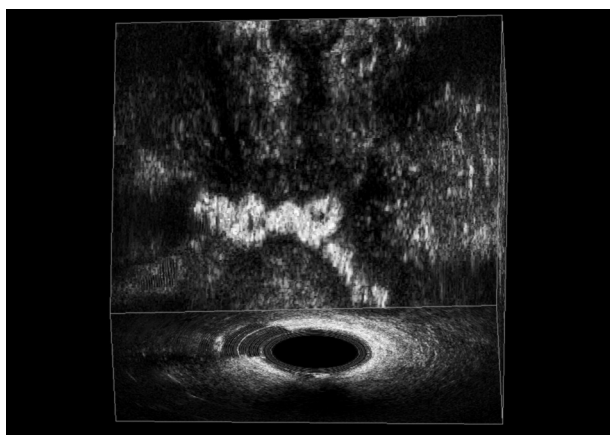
Endoanal ultrasound. Transsphincteric fistula after peroxide injection.
